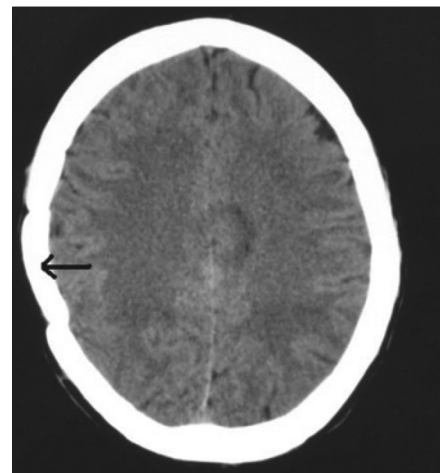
CT scan after 3 months of surgery at the time of follow up, showing previous craniotomy site with normal brain scan
